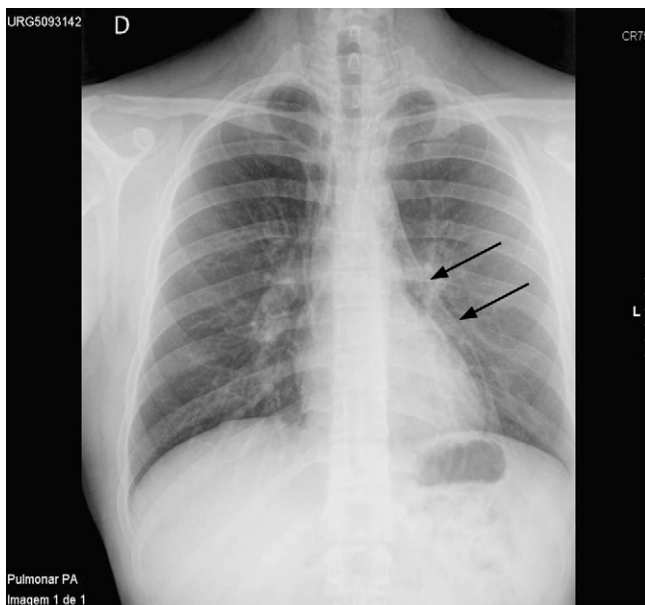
Chest x-ray showing a double line around the cardiac silhouette (arrows).
